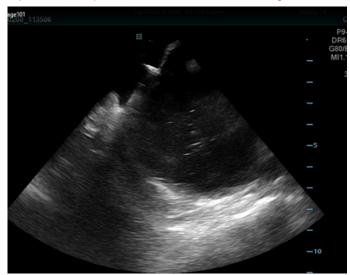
Intracardiac echocardiography to guide transseptal puncture. Presence of bubbles inside the LA is a sign that the needle passed in the LA.
